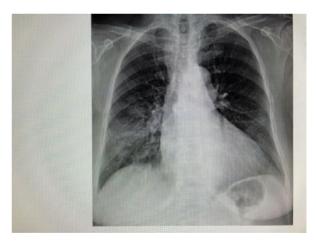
Chest radiograph 1 day after hospital discharge and upon completing 10-day course of remdesivir and high-dose dexamethasone. Progressive infiltrative process with consolidation (Case 1).
